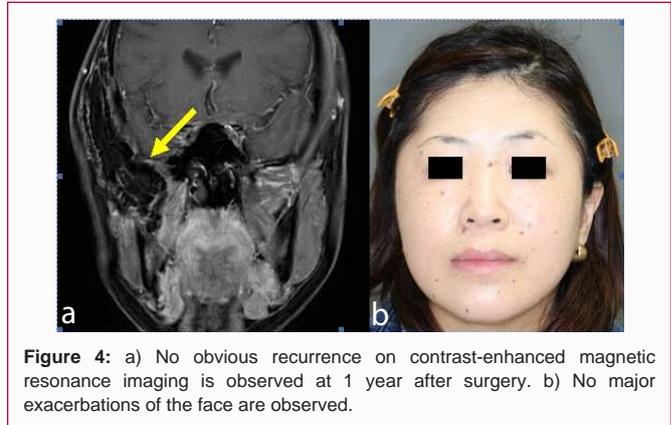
a) No obvious recurrence on contrast-enhanced magnetic resonance imaging is observed at 1 year after surgery. b) No major exacerbations of the face are observed.
